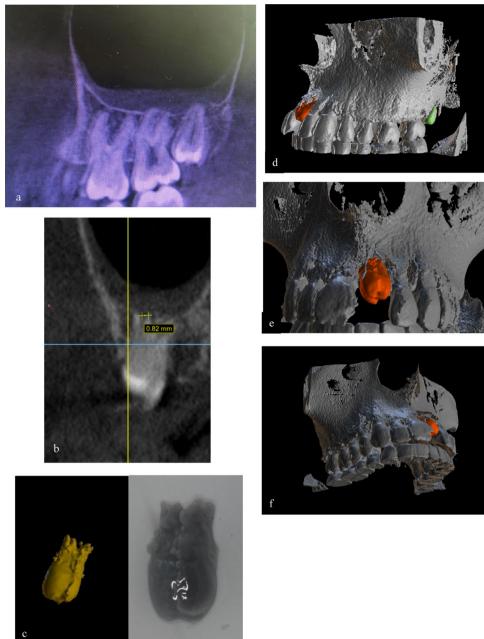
Surgical planning and printed replica. (a) CBCT showing the 28 microdontia, (b) estimated apex opening of tooth #28 (0.82 mm), (c) segmentation of tooth #28 using BlueSkyPlan open software and transplant replica (PEEK) used to prepare tooth #21 socket, (d) ideal placement of the transplant found using BlueSkyPlan. (e) frontal zoomed view of the transplant position planned, (f) lateral view of the transplant position
